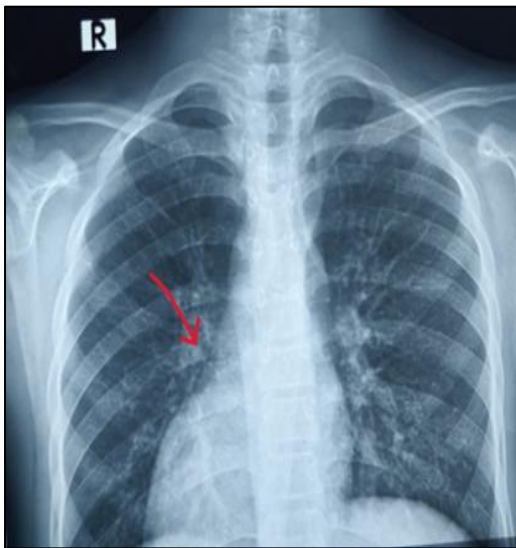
Radiograph of chest depicting dextrocardia.
